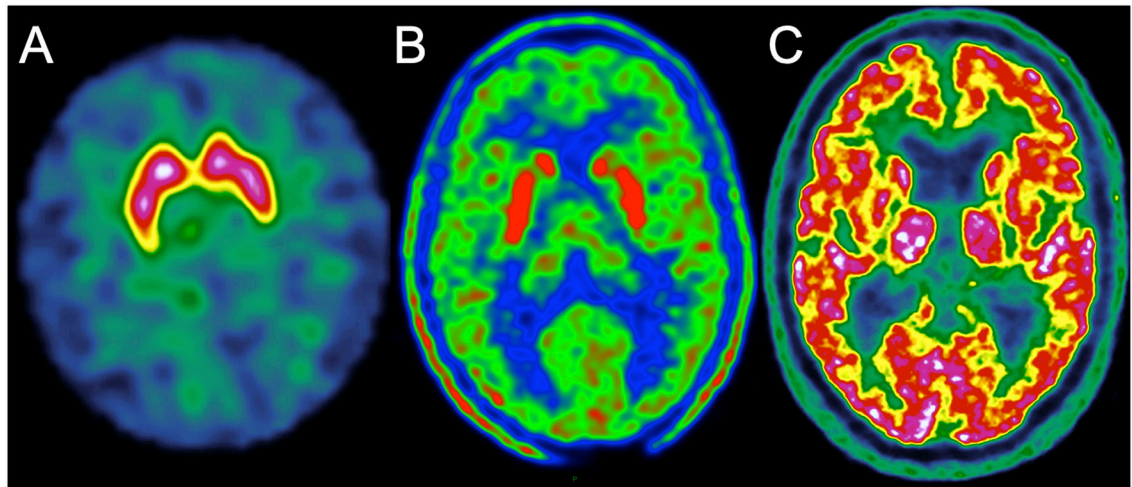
Examination of dopaminergic function using (A) Single-Photon Emission Computed Tomography (SPECT) and ^{123}I -FP-CIT (DaTSCAN ©) or (B) Positron Emission Tomography (PET) and ^{18}F -DOPA. (C) Glucose metabolism is studied using ^{18}F -fluorodesoxuglucose (^{18}F -FDG).
